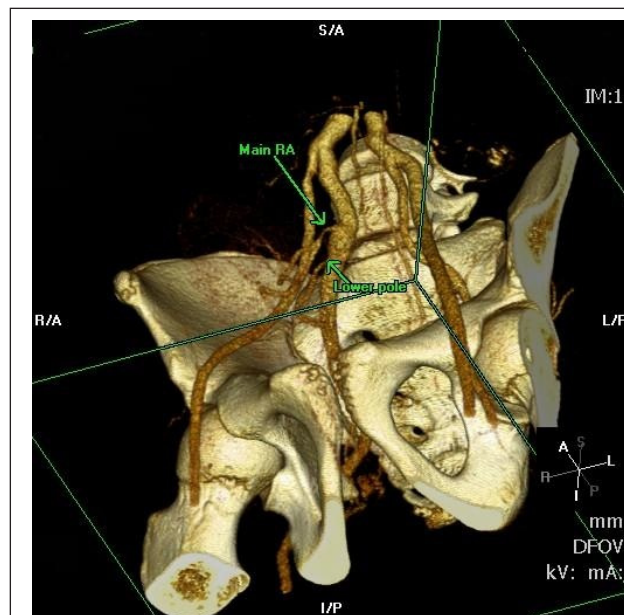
Computed tomography reconstruction image (renal transplant image subtracted) of donor Carrel patch anastomosed (two renal arteries – main and lower pole) to the side of the internal iliac artery. It can be seen in this image that the diameter of the internal iliac artery was greater than the external iliac artery.
